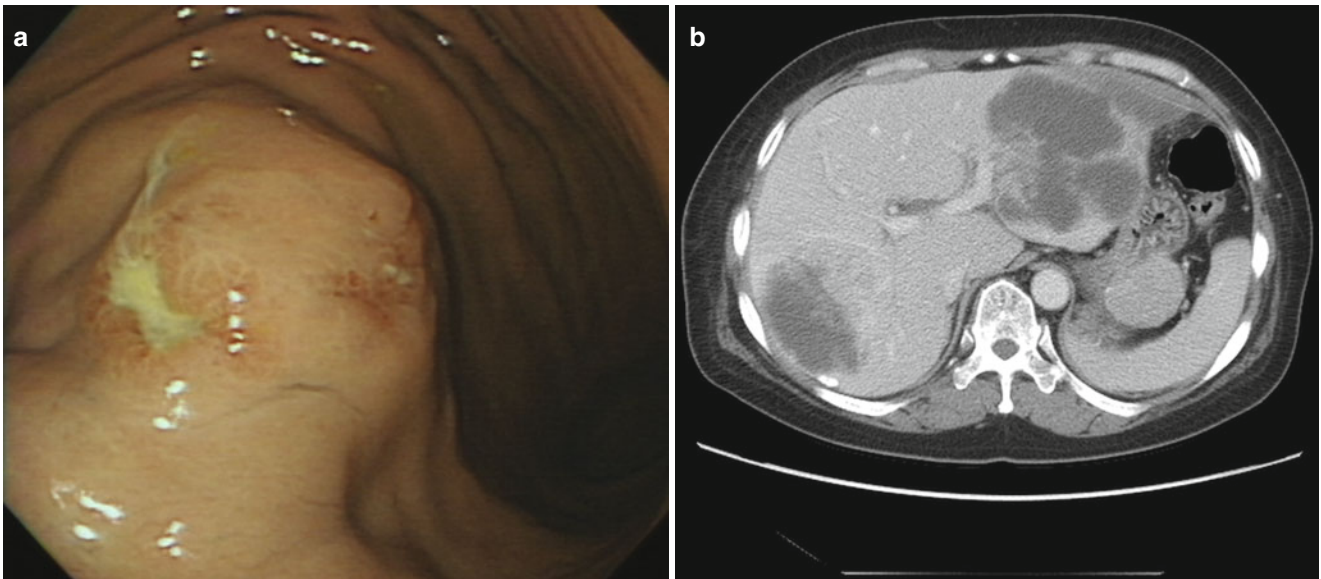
A neuroendocrine carcinoma with liver metastasis. (a) A 5-cm, round protruding subepithelial tumor with multiple ulcerations was on the greater curvature of the body. (b) Abdominal pelvic CT showed enhanced exophytic gastric mass with multiple liver metastases
